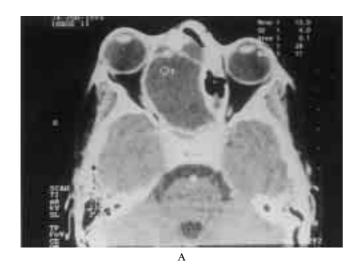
CT scan showing psammomatoid ossifying fibroma in the right ethmoid and sphenoid (A) and invading right nasal fossa and extending into the ethmoidal, maxillary sinus, causing orbital compression (B).
